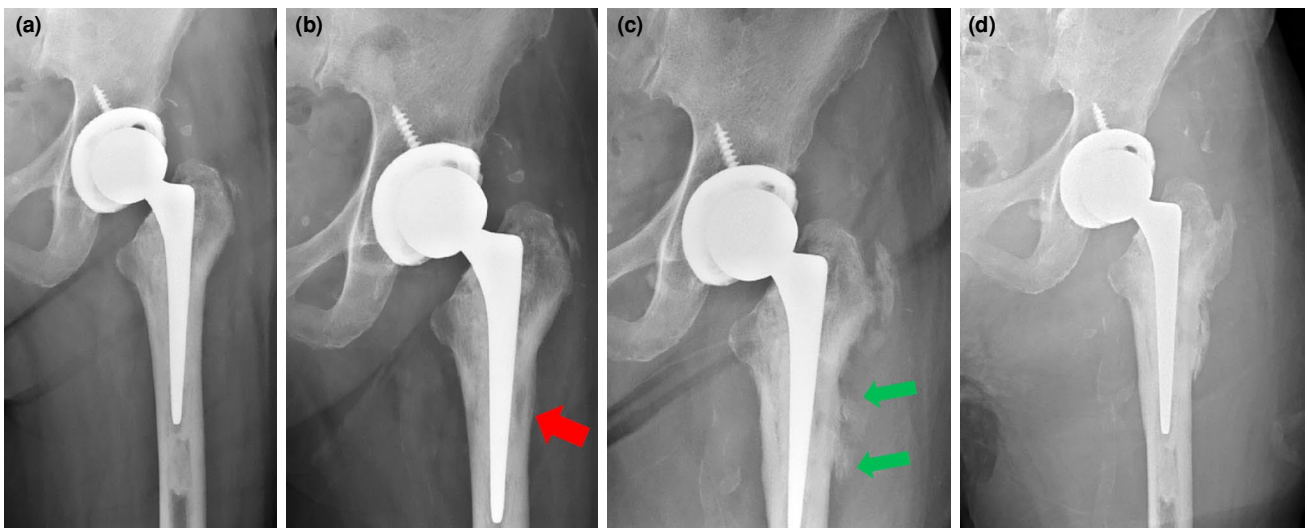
Serial plain radiographs of the left hip. (a) Taken three years prior to the dislocation event, with no obvious abnormality. (b) Taken two years prior to dislocation, showing peri-implant lucency (red arrow). (c) Taken one year prior to dislocation, showing periosteal reaction (green arrows). (d) Taken following closed reduction of the dislocated prosthetic hip.
